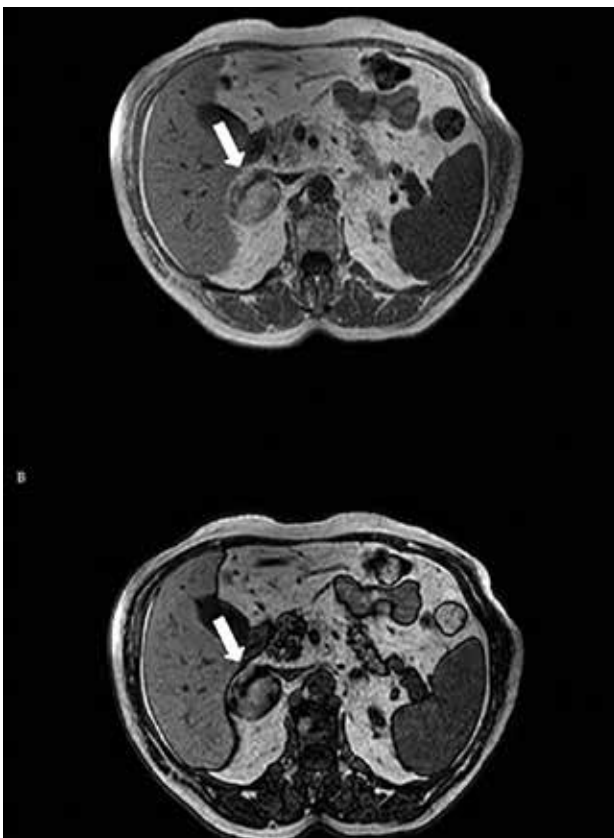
A loss of SI is displayed within adrenal myelolipoma (arrow) between the in-phase (A) and opposed-phase (B) axial CS-MRI. (Lesbats-Jacquot V, Cucchi JM, Amoretti N, Novellas S, Chevallier P, Bruneton JN. Lipomatous tumors of the adrenals – a report on 18 cases and review of the literature. *Clin Imag* 2007; 31: 335-339)
